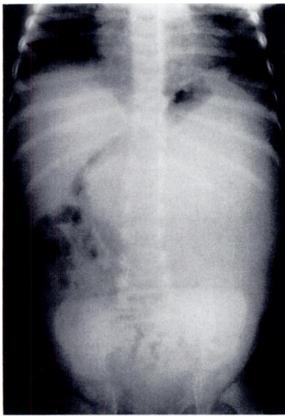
Plain abdominal radiograph of a 1-year-old boy who has neuroblastoma. Initially, abdominal mass was detected while the asymptomatic patient was bathing. This radiograph shows displacement of stomach bubble medially. Virtually all hollow viscera have been displaced to right side of peritoneal cavity by a large mass in left retroperitoneal space. The skeleton is normal radiographically.
